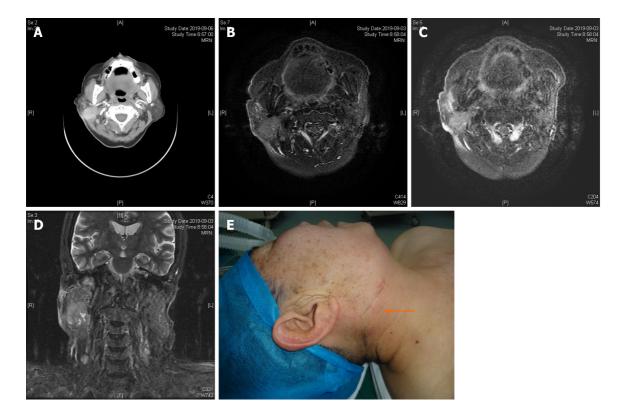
Enhanced computed tomography and magnetic resonance imaging indicated a possible malignant tumor in the right parotid gland, with involvement of adjacent skin and potential lymph node metastases. A: An approximately 28 mm × 21 mm irregular mass shadow was seen at the lower pole of the right parotid gland; B: Unclear boundaries; C: Obviously inhomogeneous enhancement; D: Thickened and enhanced adjacent skin, and multiple lymph node shadows in the right parotid gland and the right II, V regions; E: A clinical photo that shows the pre-operative appearance of the tumor.
